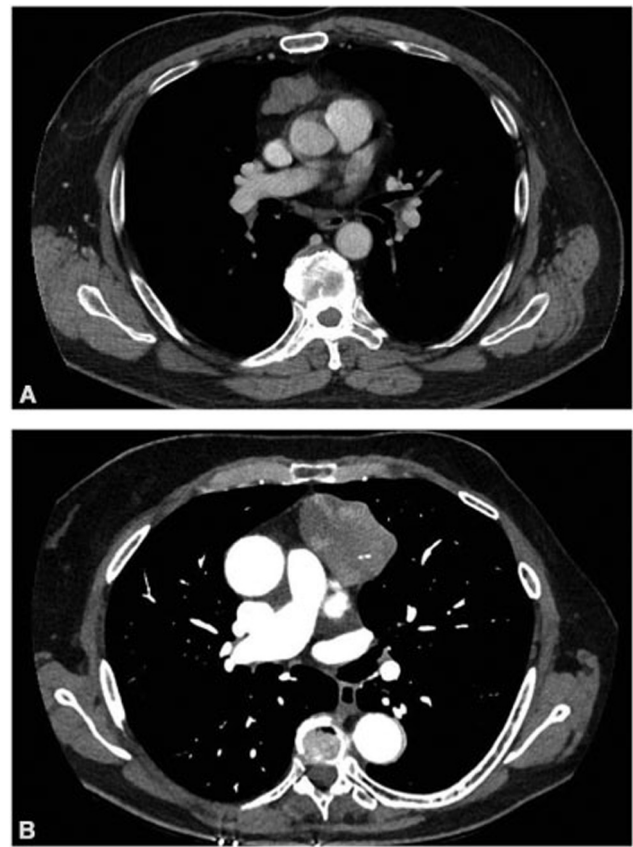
Chest CT scans showing thymomas extending predominantly on the right side (A) or to the left side (B).
